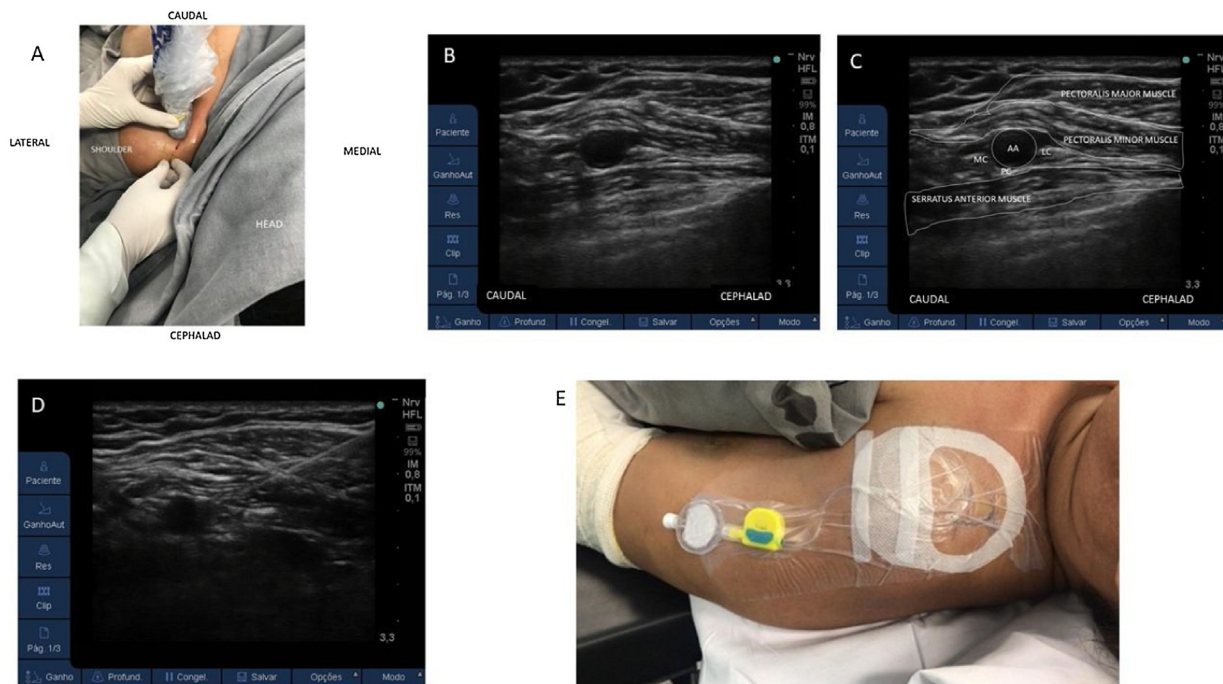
A, Positioning (patient and USG probe); B, Ultrasound image; C, Ultrasonographic anatomy. Axillary Artery (AA), Lateral Cord (LC), Posterior Cord (PC), and Medial Cord (MC). D, Needle in-plane toward the lateral and posterior cord. E, Insertion, and fixation of peripheral nerve catheter in the infraclavicular brachial plexus.
